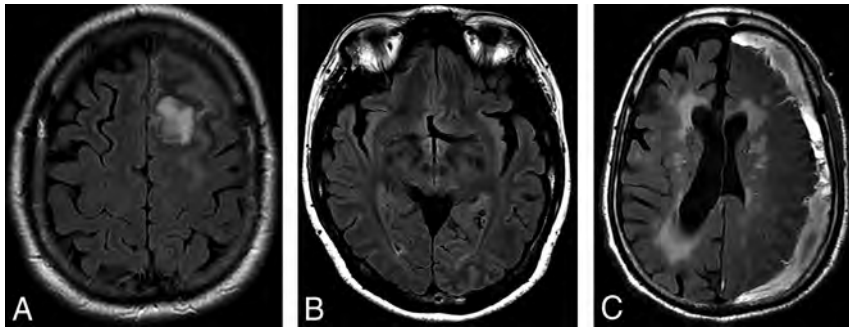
A, T2 FLAIR images from a 49-year-old male patient being followed for a left-frontal meningioma with asymptomatic low signal in the subcortical white matter adjacent to the meningioma. Nonspecific failure of suppression of CSF signal in the subjacent sulci was also noted. B, T2 FLAIR images showing low signal in the left occipital lobe in a 46-year-old patient who initially presented with visual seizures. C, T2 FLAIR images from a 48-year-old patient with a left convexity subdural hematoma and seizures. Subcortical low T2 signal is present in the compressed posterior frontal and parietal lobes.
